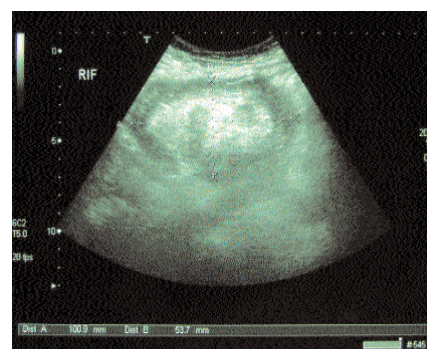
Ultrasound picture showing the 'pseudo-kidney' sign in right iliac fossa.
